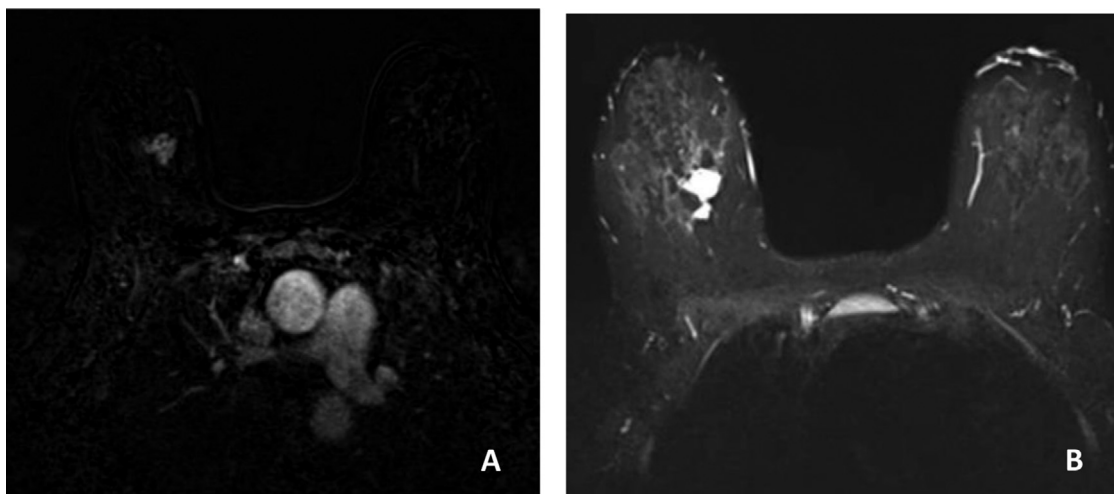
A Axial T2- weighted TIRM MR sequence shows homogeneous hyperintense irregular mass. B, on early phase image of dynamic enhancement MRI, tumor shows irregular shape and irregular margin with heterogeneous enhancement is seen.
